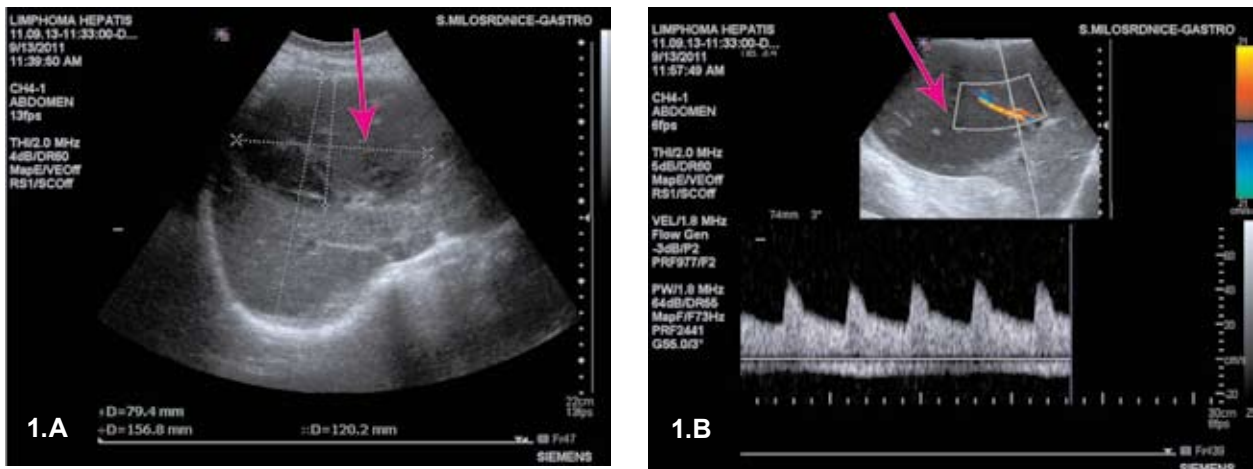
Abdominal ultrasound showing; A) a hypoechoic lesion 12x8 cm in the right liver lobe; B) without change of ultrasound structure.
